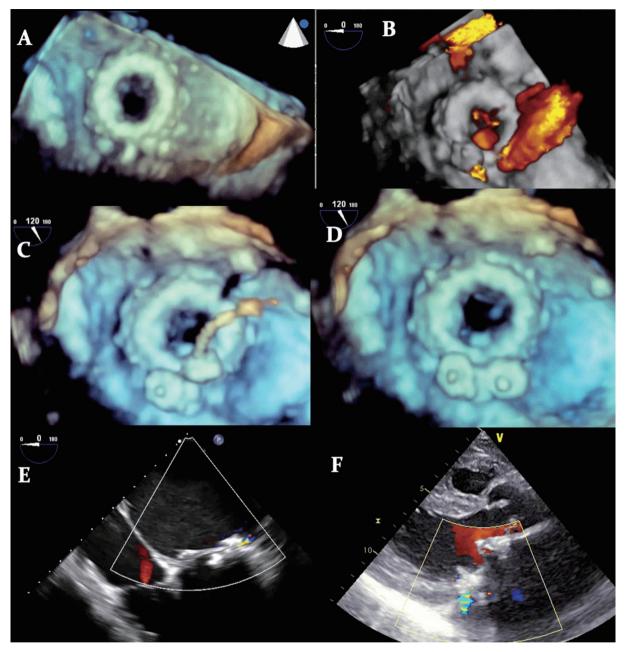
(A) 3D trans-esophageal echocardiography shows para-valvular defect at posterior aspect of mitral xenograft (white and red arrows indicate different orifices of the mitral regurgitation jet). (B) 3D trans-esophageal echocardiography color view shows the residual para-valvular leak after deployment of the first AVP II. (C) Deploying the second AVP II (3D trans-esophageal echocardiography). (D) Final result after deployment of the third AVP II. (E) Trace residual para-valvular leak after the procedure (2D trans-esophageal echocardiography). (F) Follow-up trans-thoracic echocardiography, one year after the procedure.
